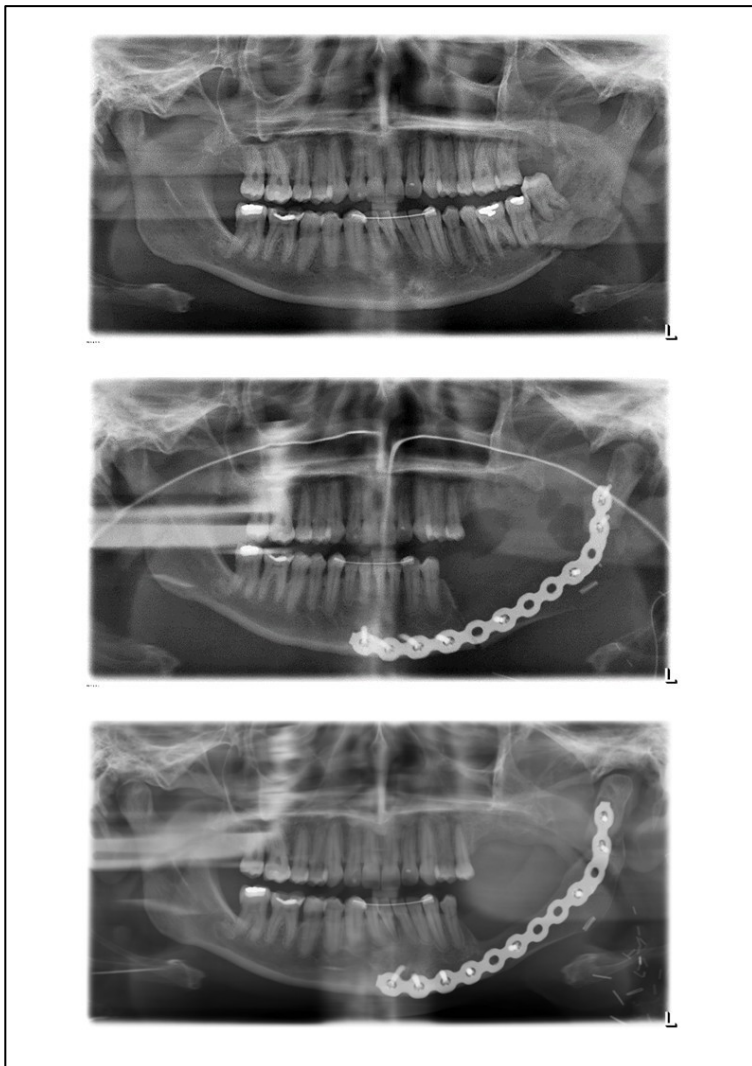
The x-ray images (orthopantomogram) show the progression over time. The first image shows the preoperative initial situation with osteoradionecrosis. The second image shows the inpatient stay after mandible resection and reconstruction, with still remaining nasogastric tube. The third image shows the final follow-up visit with the 12 months postoperative situation after healing.
